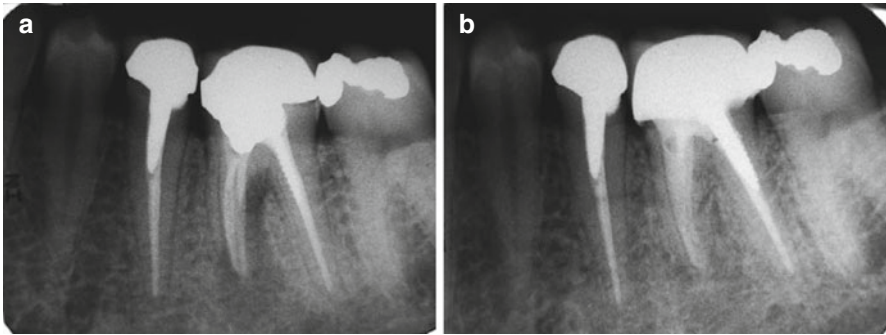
(a, b) The need for meticulous clinical examination to achieve accurate VRF diagnosis is emphasized in Figs. 5.14, 5.15, and 5.16. A periapical radiograph shows well-condensed gutta-percha filling in the mesial root of a mandibular molar, an amalgam dowel, and typical “halo” radiolucency around the mesial root combined with radiolucency in the bifurcation. Since there were no other signs or symptoms to make a VRF diagnosis, a diagnosis of asymptomatic apical periodontitis was made and the patient scheduled for retreatment (a). Complete healing of the radiolucency can be seen 1 year after retreatment (b) and a new restoration (Courtesy Dr. Z. Elkes)
